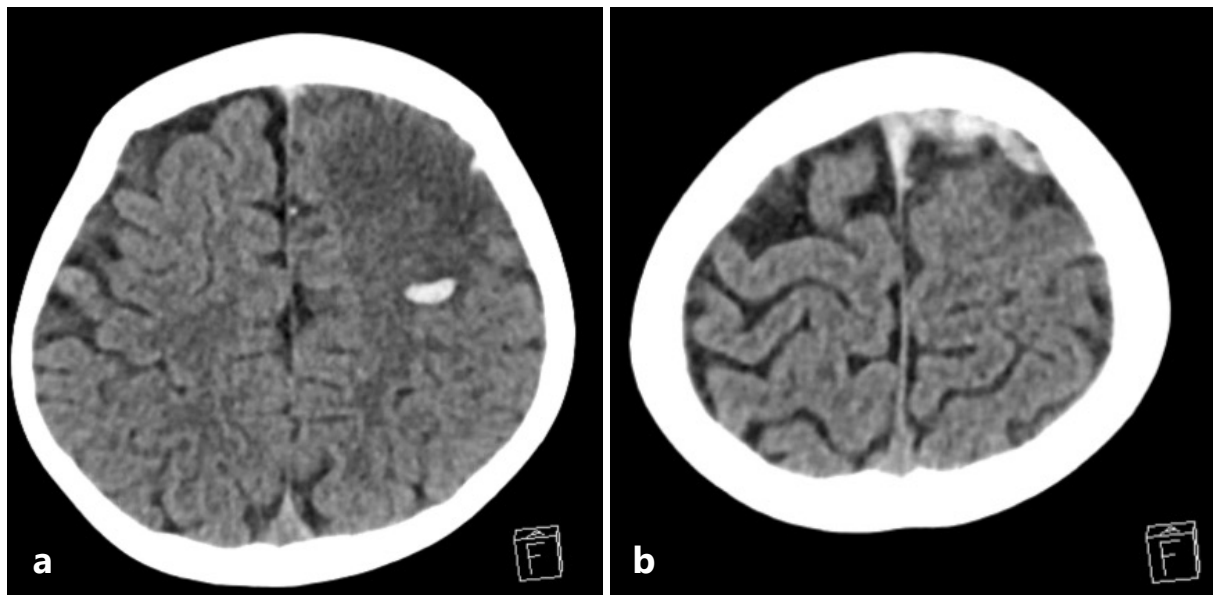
Non-enhanced CT brain of a 6-year-old boy with acute lymphoblastic leukaemia who had received L-asparaginase and high-dose corticosteroids. (a) Hypodensity involving the left frontal lobe with loss of grey-white differentiation, suggestive of a recent infarct with an acute haematoma. (b) Hyperdensity within the superior sagittal sinus near the vertex with extra-axial curvilinear hyperdensities, suggestive of venous thrombosis and subdural haemorrhage.*
